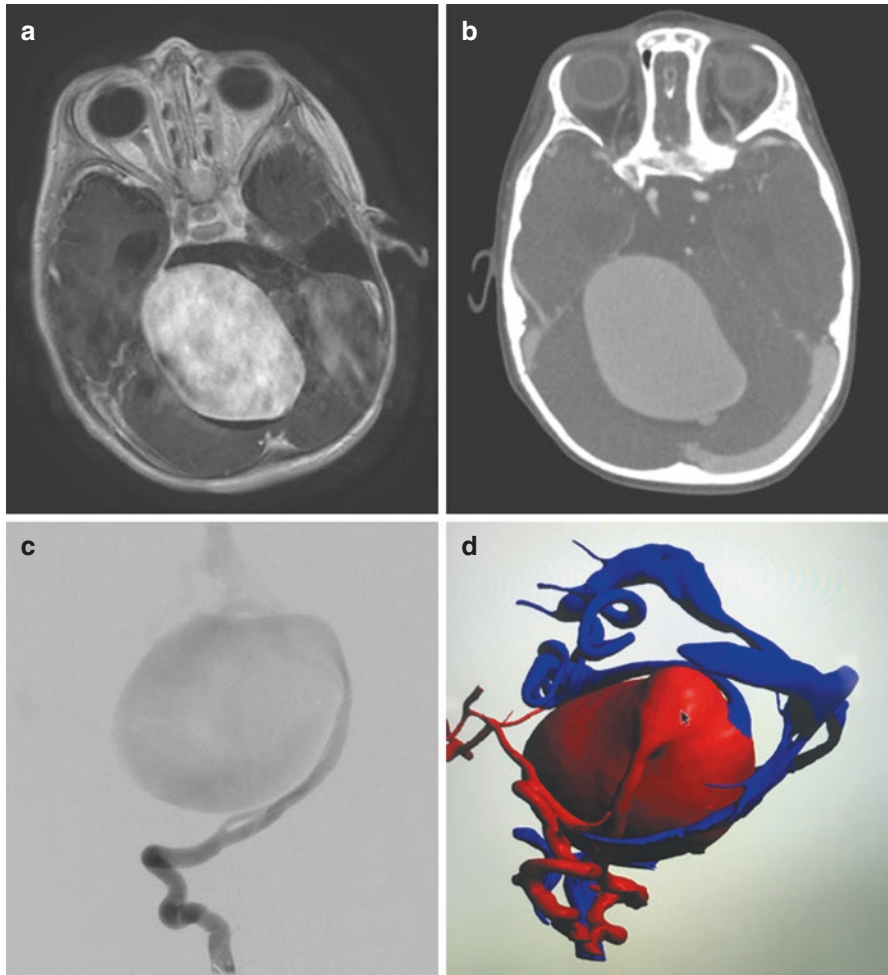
21-month-old male found to have a giant posterior fossa aneurysmal AV malformation diagnosed during work up for motor and speech delay. (a) MRI with contrast, (b) CT angiogram, (c) DCA, (d) 3D reconstruction demonstrating arterial inflow and venous outflow from aneurysm
